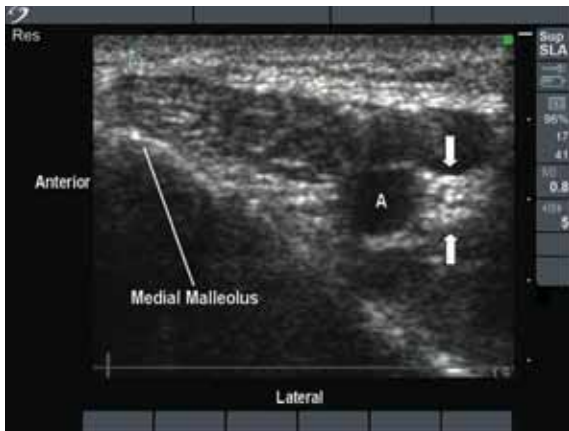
Ultrasound image of the tibial nerve and surrounding structures.
